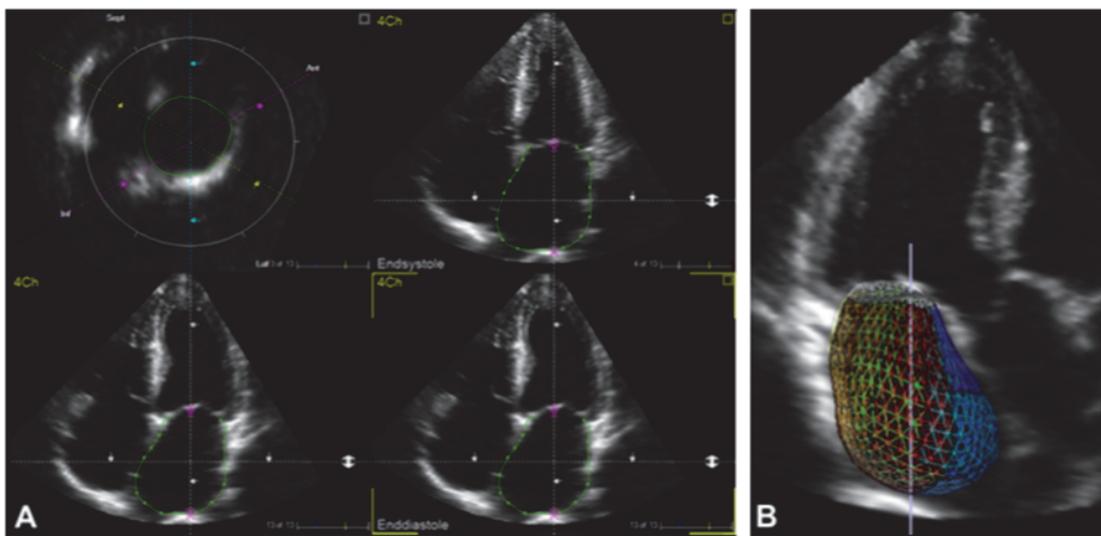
Left atrial chamber quantification using 40 LA Analysis. Manual contouring is required at end-systole and end-diastole in apical 4-chamber (A), 3-chamber, and 2-chamber views, before a polyhedron-model (B) is automatically created based on left atrial endocardial border tracing and the corresponding volumes are calculated.
